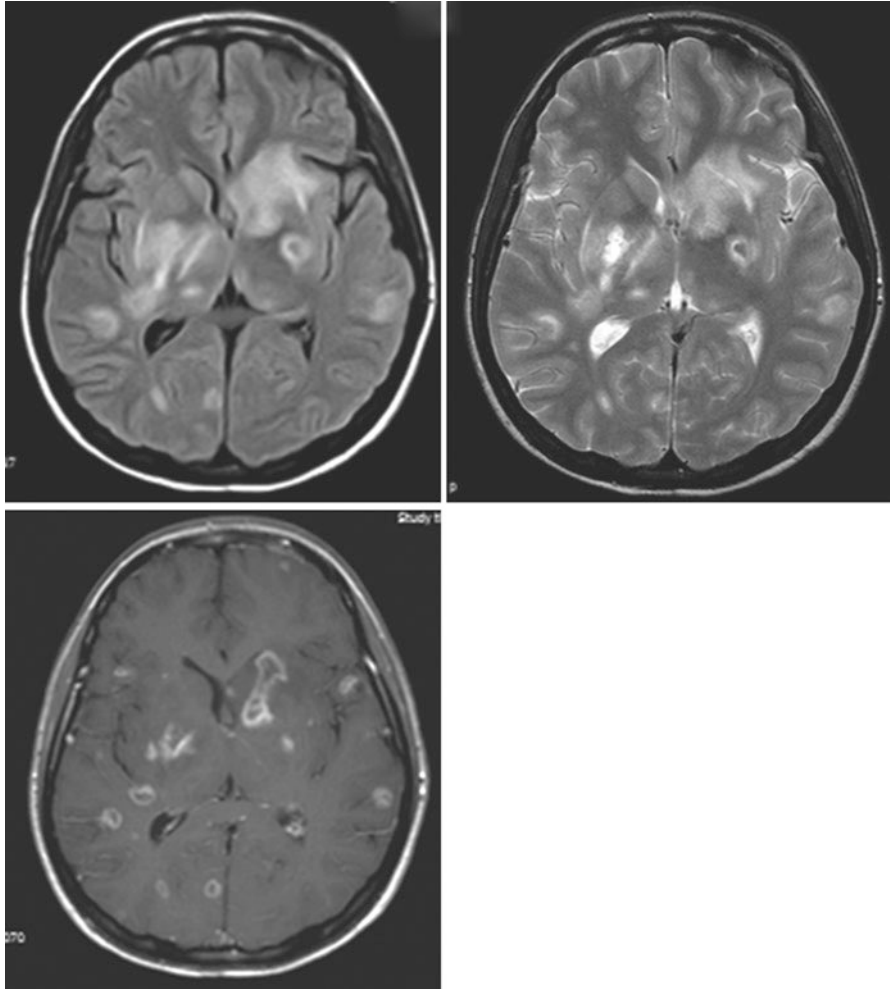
FLAIR, T2-weighted, and contrast-enhanced T1-weighted MRIs of patient with AIDS and cerebral toxoplasmosis. Note multiplicity of lesions, predominance of involvement of the basal ganglia, and ring enhancement of most of them
